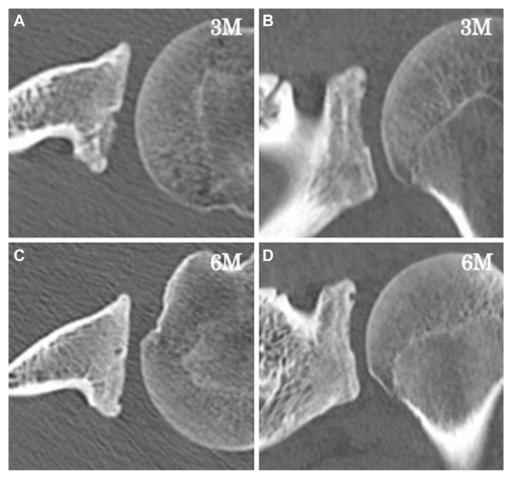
Computed tomography 3 months after surgery (A, B) showed restoration of the lesion and 6 months after surgery (C, D) showed complete healing.
